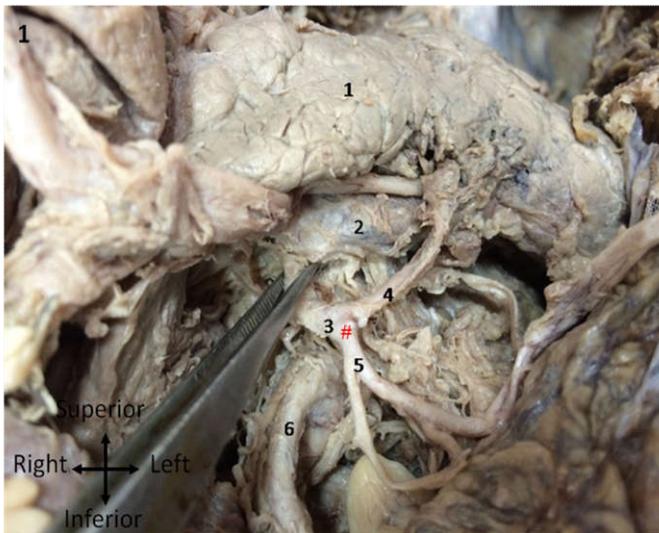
Variation of branching pattern of celiac trunk. CT was divided into left gastric artery, splenic artery and common hepatic artery. Note pancreas, celiac trunk, middle colic artery and its branches and superior mesenteric artery. 1- Pancreas, 2- Celiac trunk, 3-(#) Middle colic artery, 4- Branch of middle colic artery to the pancreas, 5- Branch of middle colic artery to the transverse colon, 6- Superior mesenteric artery.
